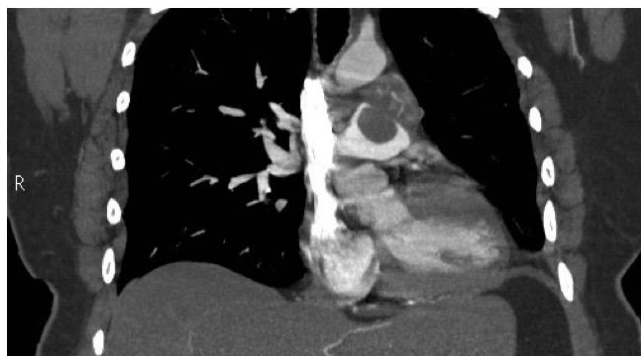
Coronally reformatted CTA of the chest demonstrating a large filling defect in the main and left pulmonary arteries with prominent vascularity.
